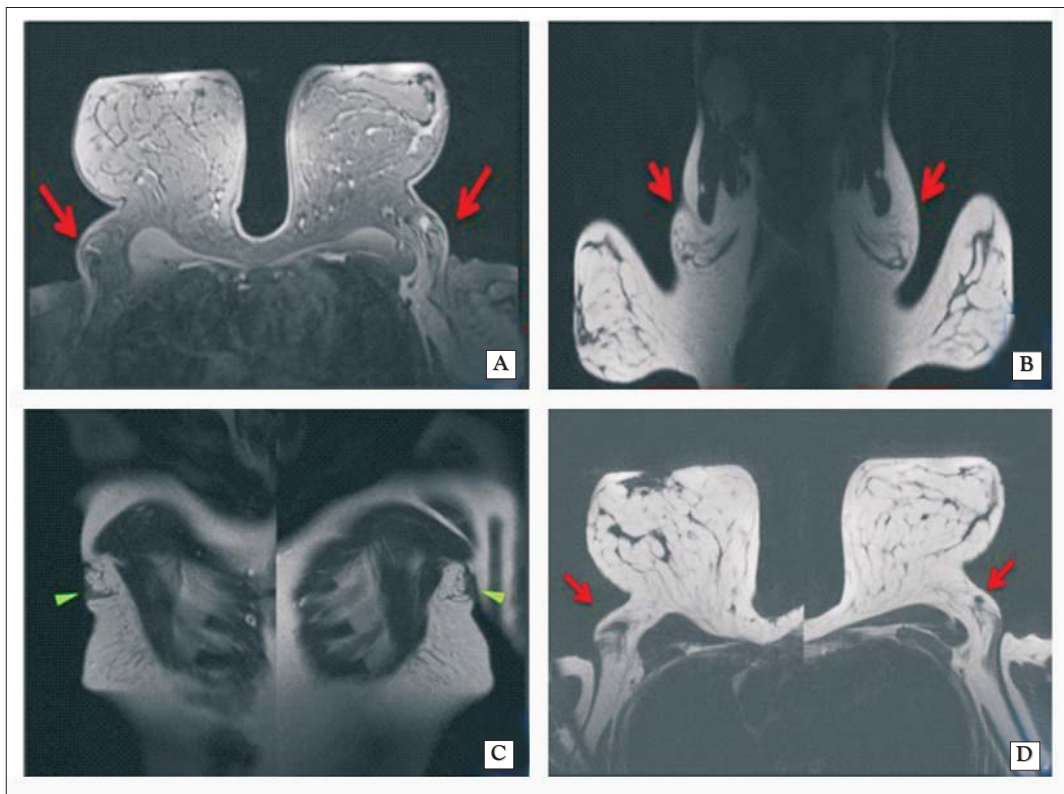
MRI scan: bilateral axillary breast tissue unrelated with the eutopic breast (A,B,D – red arrows); rudimentary nipples (C – green arrows)
